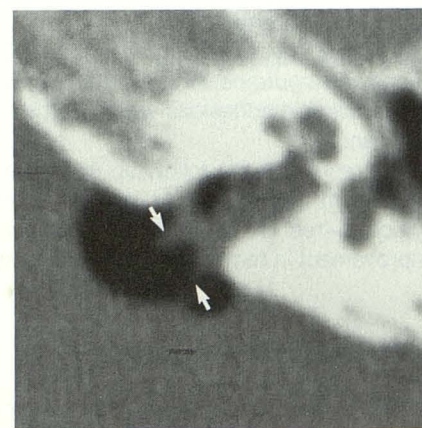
Case 26: Left air CT cisternogram shows vascular loop at porus acusticus protruding into internal auditory canal (arrows) and contacting neurovascular bundle.
